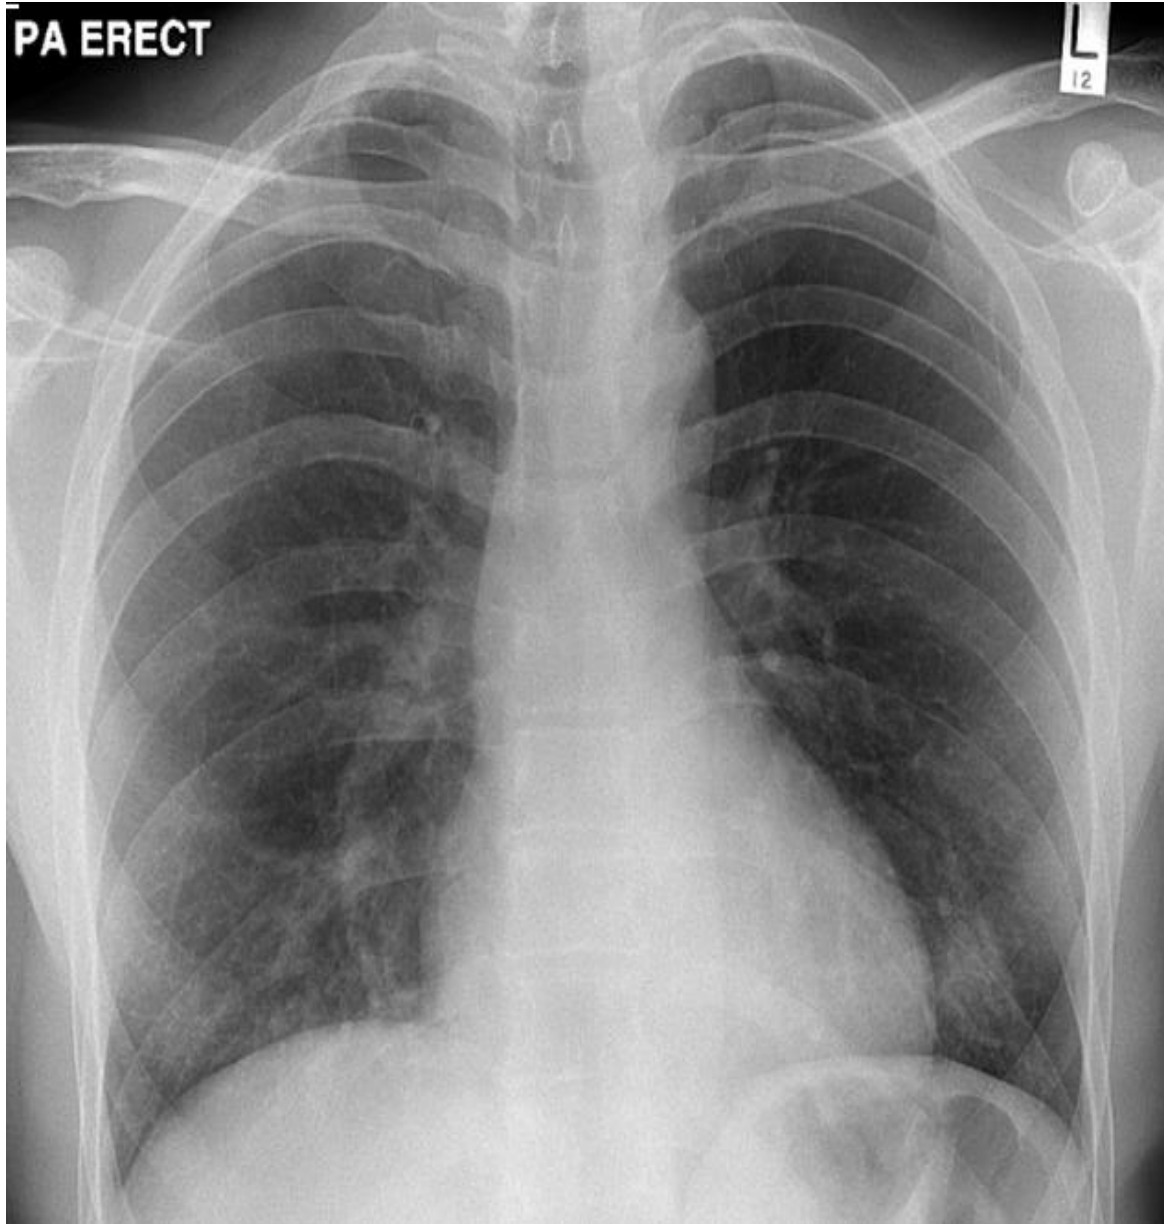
Chest x-ray of male contact at day 8 of the patient's treatment.
